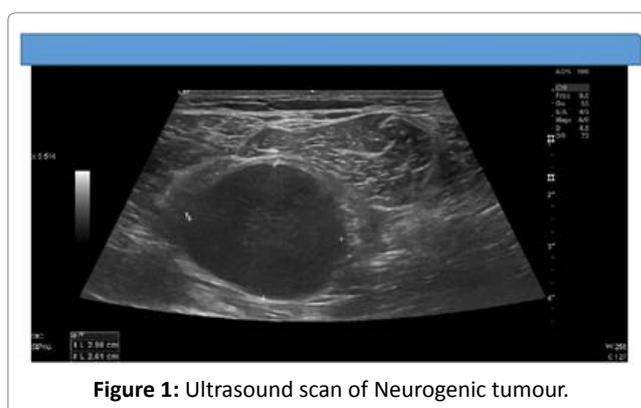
Ultrasound scan of Neurogenic tumour.
